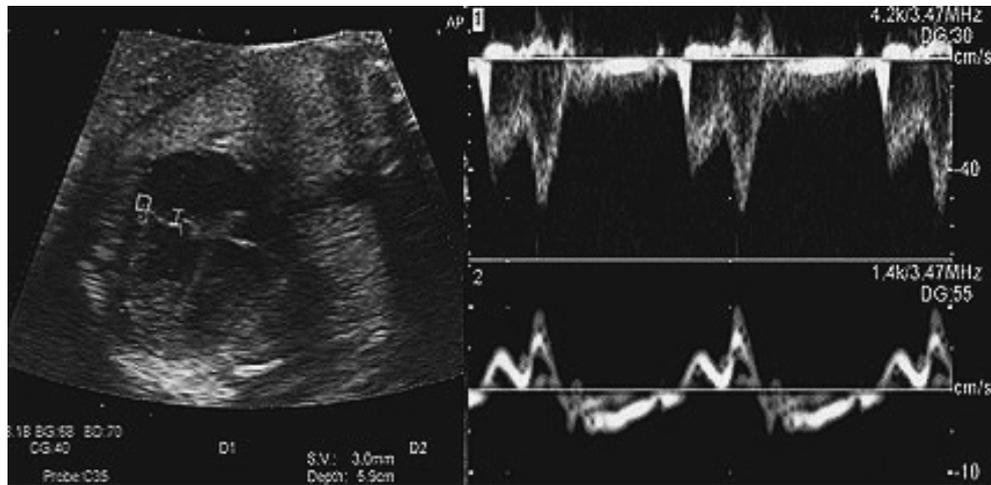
The ultrasonogram for assessment of E/e' by the Dual gate Doppler method. The upper Doppler waveform is obtained using pulsed wave Doppler imaging, whereas the lower waveform is obtained using tissue Doppler imaging. In the Dual gate Doppler method, velocities of E and e' wave are measured in the identical cardiac cycle.
